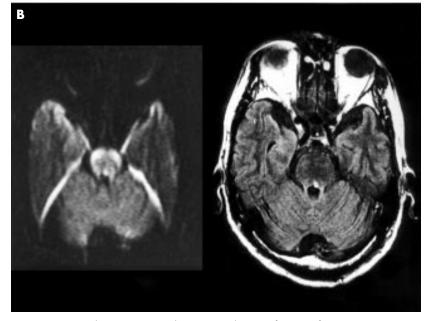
(A) Ocular impairment in the patient at the time of onset. Left exotropia was present on forward gaze without blepharoptosis. Adduction of left eye was disturbed and it never reached beyond the midline of the orbit, although full abduction was possible. Right ocular movement was not disturbed in any direction, but horizontal nystagmus appeared on rightward gaze. There was deficiency of left convergence. Vertical ocular movement of both eyes was undisturbed. (B) Cerebral magnetic resonance imaging (MRI): a tiny isolated lesion was present at the left paramedian pontine tegmentum just adjacent to the fourth ventricle on both axial fluid attenuated inversion recovery (FLAIR) imaging (right) and diffusion weighted MRI (left). The tiny lesion causing WEMINO syndrome showed high signal intensity on both MRI modes.
